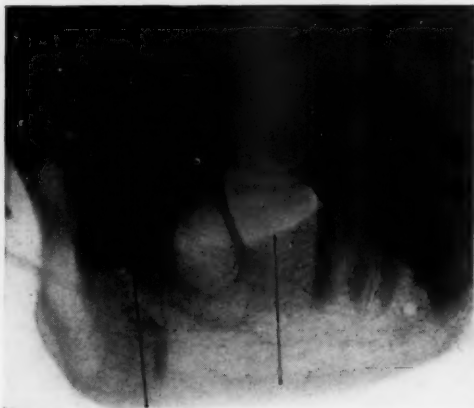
(Case 2.) Roentgenogram showing unilocular cavity in mandible due to adamantinoma (Doctors Pancoast and Pendergrass). The tissue between the vertical lines was resected.
